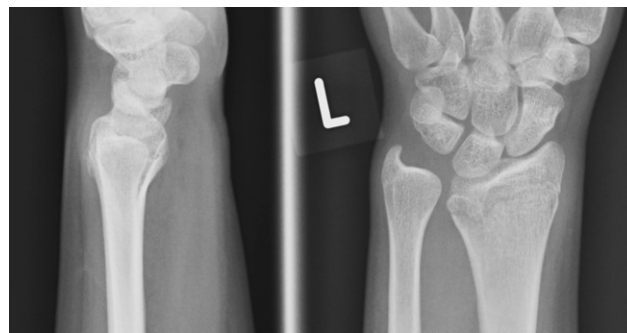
Postero-anterior radiograph of the wrist revealing subtle Madelung's deformity discovered incidentally following injury to the wrist: the V-carpus and prominent ulnar can be seen.
